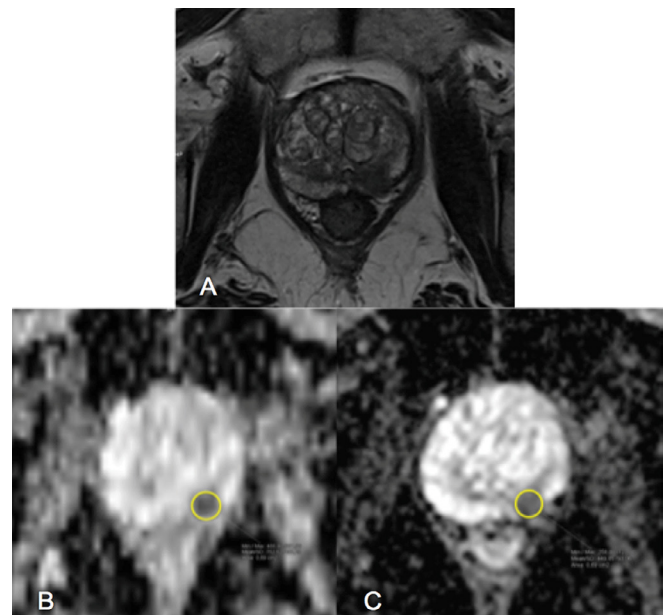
Representative magnetic resonance imaging in patient with a prostate lesion
